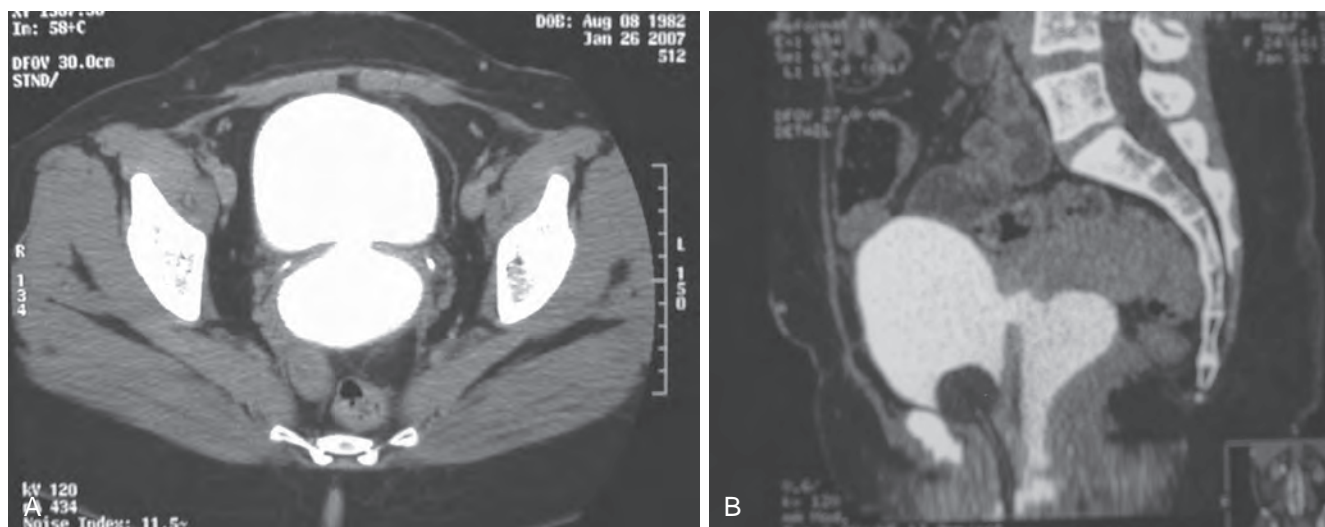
Computed tomography (CT) scan of vesicovaginal fistula (VVF). A, After intravenous administration of the contrast agent, there is high-density material in both the bladder and vagina consistent with a VVF. The fistulous connection is between the bladder anteriorly and the vagina posteriorly. B, Sagittal CT reconstruction demonstrating VVF.
